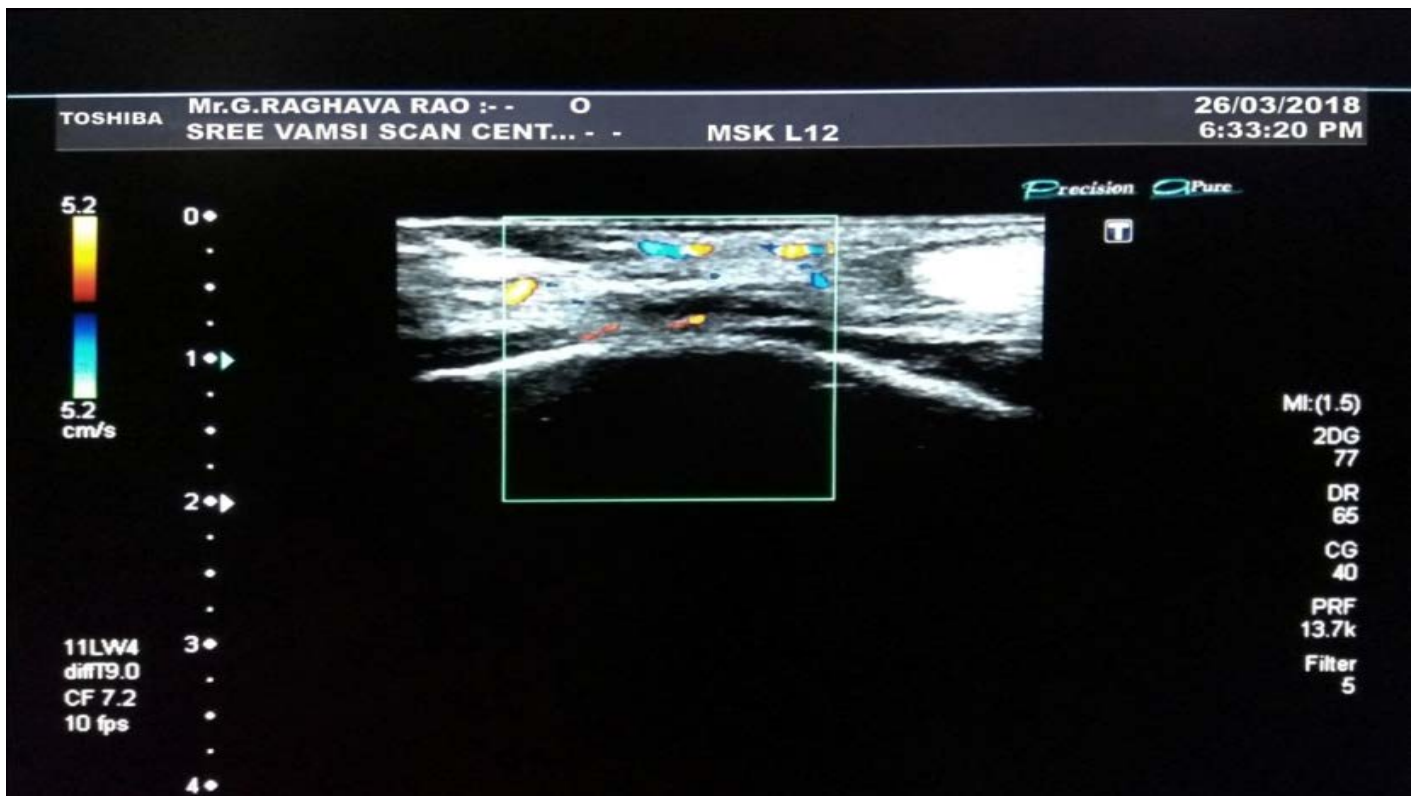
Site A ultrasound Doppler flowmetry indicating number of vascular channels and Doppler velocity at 10 days
